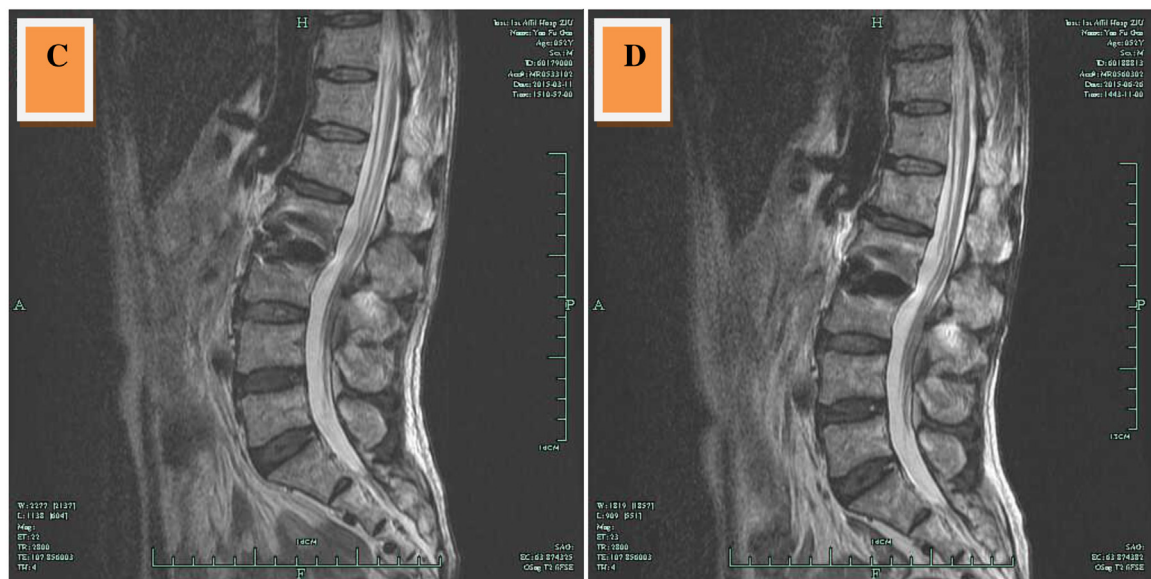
A control lumbar MRI after two months of treatment (C) and four months of follow-up (D) showed gradual improvement radiologically and only the sequel lesions at the site of the infection (T2 sagittal).
